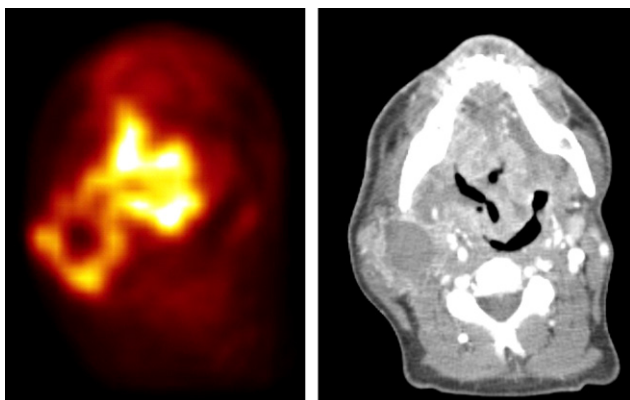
FDG PET (left) and CT (right) of a patient with tonsil carcinoma right and bicervical lymph node metastasis before start of irradiation therapy showing intratumoural heterogeneity of FDG uptake.
